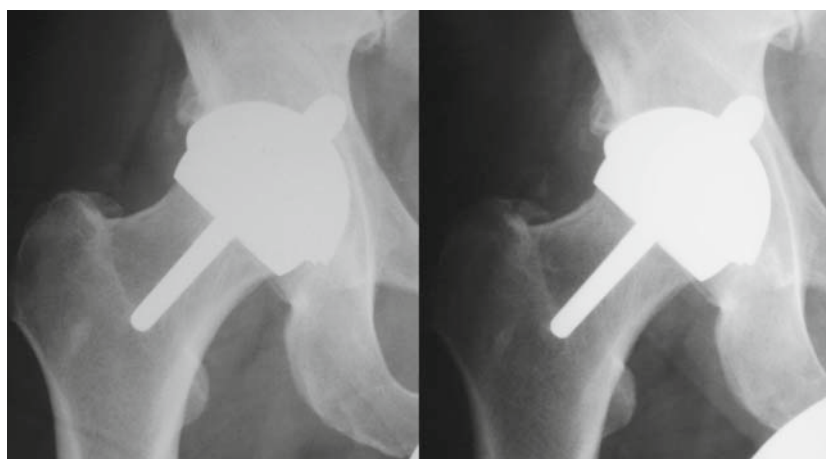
Perfect radiographic outcome 2 years and 12.7 years after McMinn Hybrid Resurfacing performed in 1994. The patient is a keen golfer with a 6 handicap.
